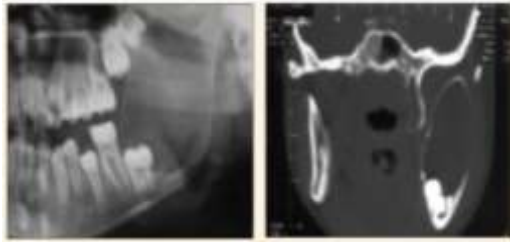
A Ameloblastoma on the mandibular sinistra at Plainphoto, as a broad lesion and expansionist (B) CT scans of coronal pieces showing widespread lesions of expansion, thinning of the cortex and minimal destruction (C) CT scans show the ameloblastoma on the maxillary sinus and the cavum of rice. Radiography and surgical explorations indicate the underlying sinus base (D) CT scan of the coronal piece of the broad ameloblastoma that satisfies the sinistra maxillary sinus and the cavum rice with lateral sinus wall bone erosion and the base of the Orbita (source Gumgum S Hosgoren B, 2005, Schafer DR, 1998)
